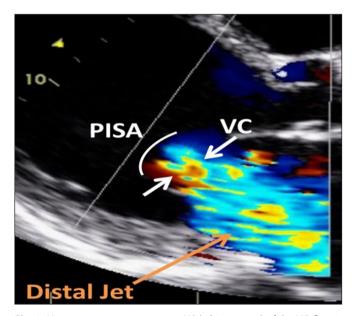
Vena contracta measurement. VC (white arrows) of the MR flow is measured from the parasternal view along the long-axis as the narrowest part of the proximal flow at the level of the tips of the leaflets or slightly distal to them [10].
